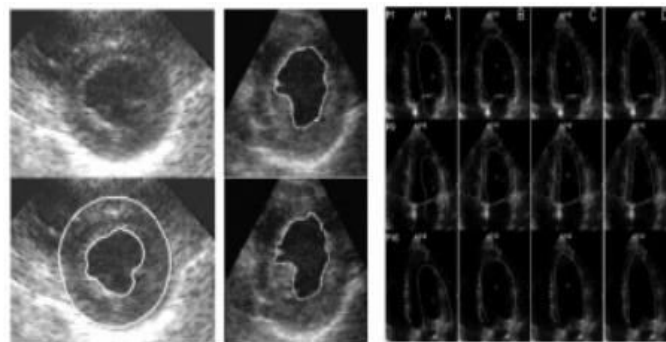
Examples of echocardiographic image segmentation.
